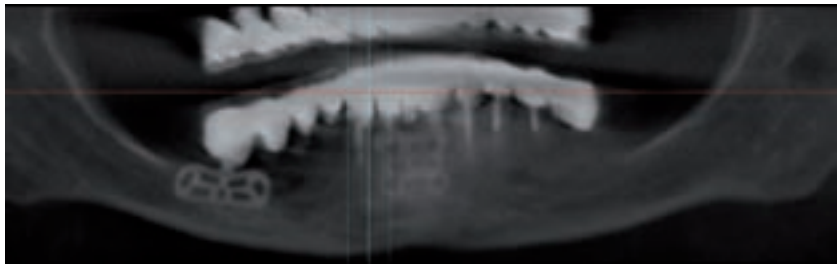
Panoramic radiograph revealing three remaining natural teeth in the left posterior quadrant, each having had root canal therapy and post fabrication which exhibited swelling intraorally. Note the two endosseous blade form implants.
